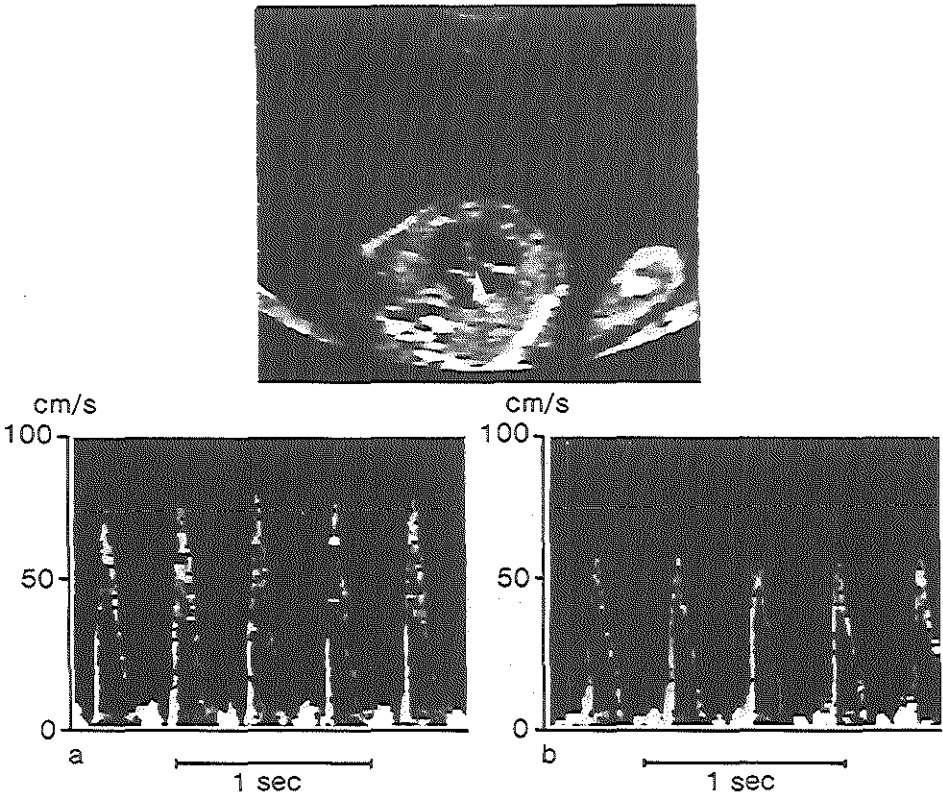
Two-dimensional "five-chamber" view of the human fetal heart with Doppler flow velocity waveforms from the ascending aorta (arrow) during normal pregnancy (a) and IUGR (b).
